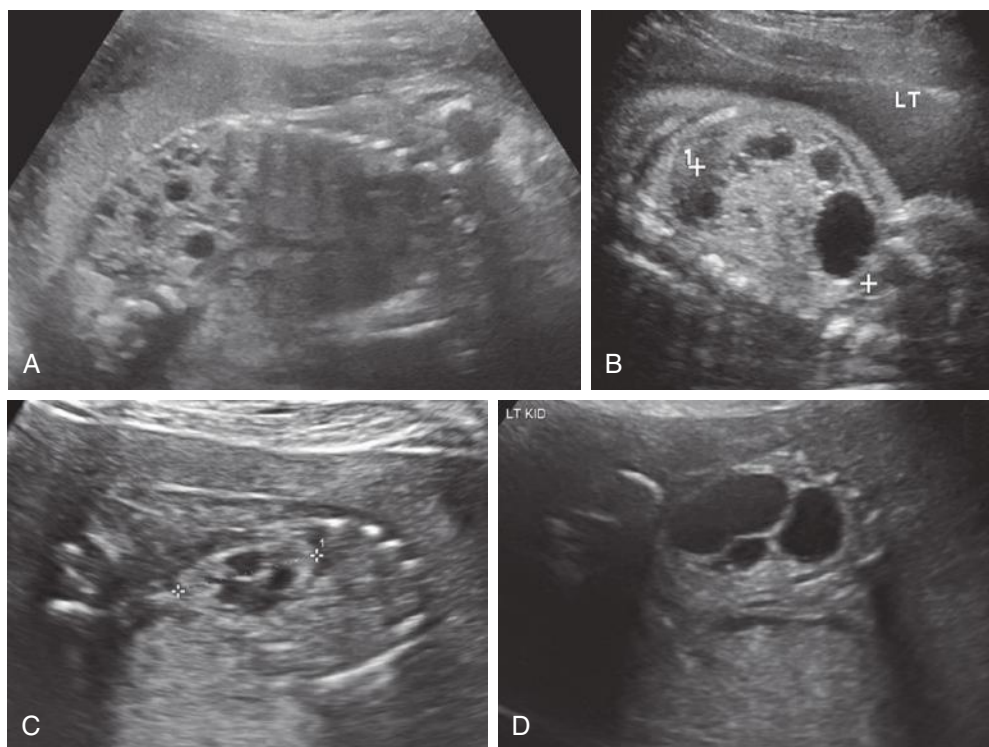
Multicystic dysplastic kidney (MCDK). Images A-D demonstrate variable appearance in second trimester fetuses. Features include noncommunicating cysts of variable size, variable amount of hyperechoic stroma, no normal cortex or medulla, irregular renal contours, and no identifiable collecting system. The abnormal MCDK is delineated by the calipers in B and C. LT, left. (C and D, Courtesy Department of Obstetrics and Gynecology, Yale University School of Medicine, New Haven, CT.)
